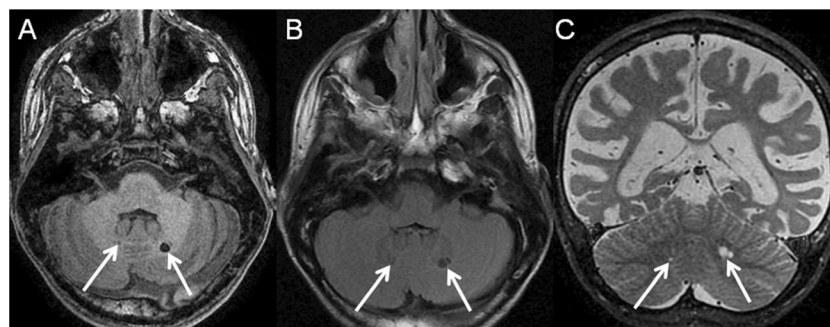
A 10-year-old child assessed for developmental regression. A diagnosis of MPS III-A (Sanfilippo) was confirmed. Axial T1-weighted (a), axial fluid attenuation inversion recovery (FLAIR) (b), and coronal
